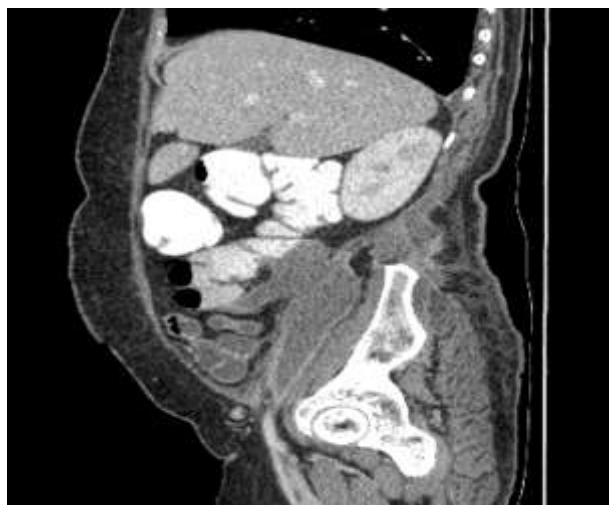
Contrast enhanced CT abdomen, venous phase(a) Coronal ,shows grossly dilated appendix with lobulated irregular appearance (b) Axial section ,appendix communicating with well defined peripherally enhancing hypodense collection epicentered in posterior pararenal space.Collection extending laterally to subcutaneous plane in right iliac fossa.Medially involving right iliopsoas and iliacus muscle.(c)Saggital section, retroperitoneal extension of collection.
